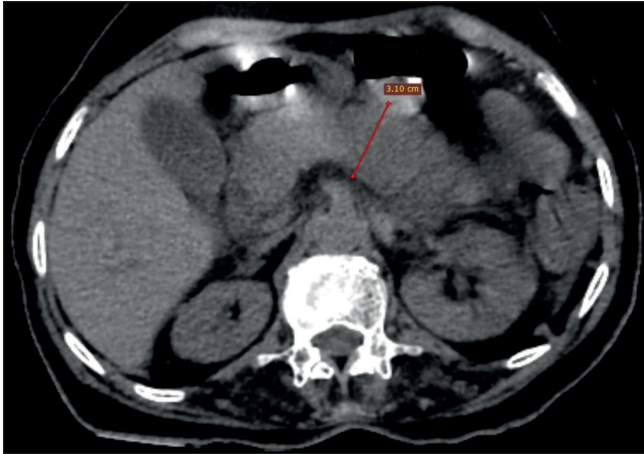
Plain CT axial view showing enlarged pancreas with fluid in the tail region with peripancreatic fat stranding.
